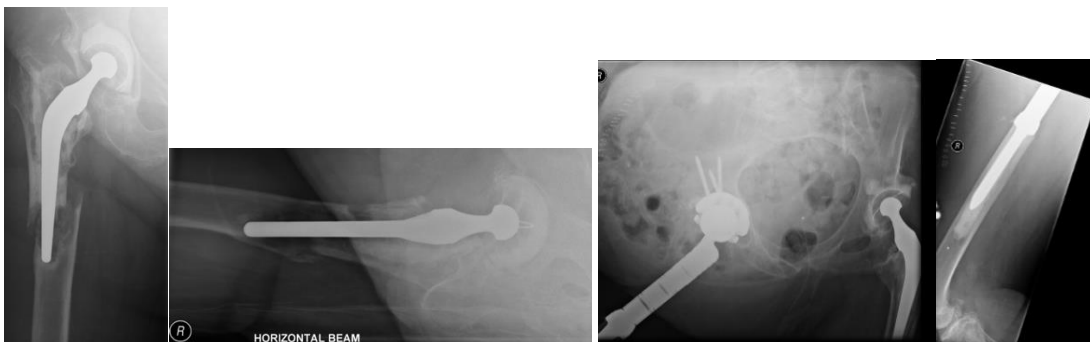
Pre-operative radiograph in 2017 and Immediate post-operative radiograph
